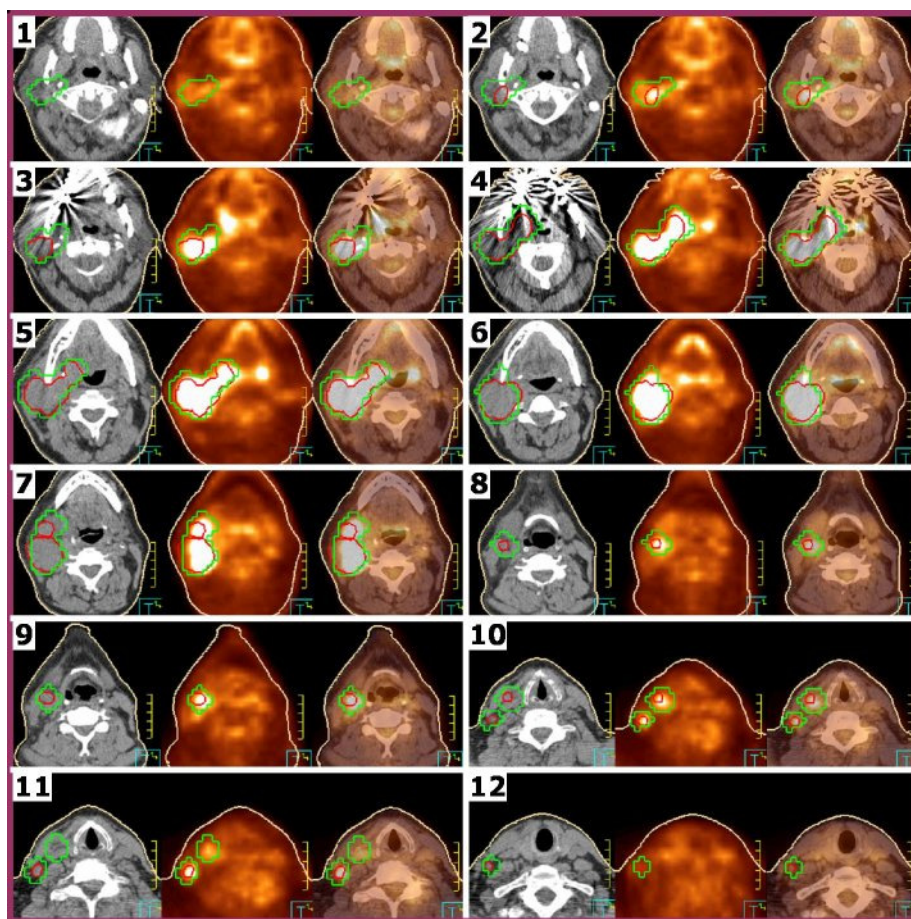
A series of CT, PET, and fused PET/CT transaxial slices for H&N case one showing the radiologist-delineation (green), oncologist-delineation (red) and the patient's outline (light-brown).
